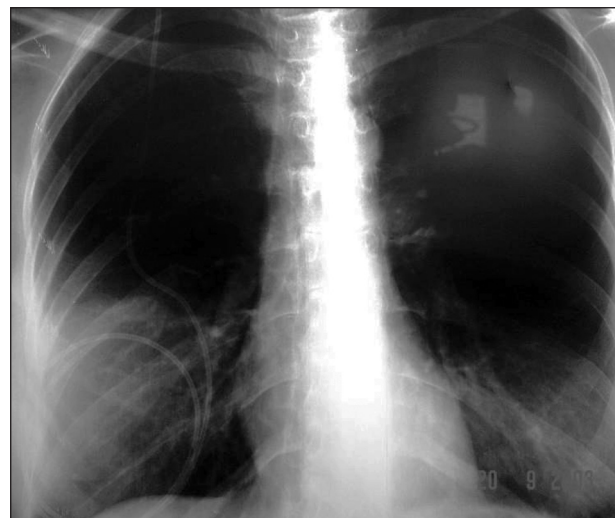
Chest X-ray showing the distal catheter coiled in the region of the right breast of the patient.
